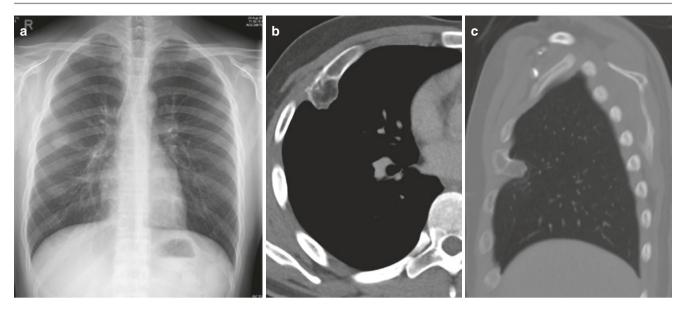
Exostosis mimicking a lung nodule. (a) Frontal chest radiograph with a nodular opacity in the right mid-zone. Note the inner margins of nodule are sharp, while the lateral margin is blur (incomplete border sign). (b, c) Axial and sagittal CT images show exostoses growing inward
